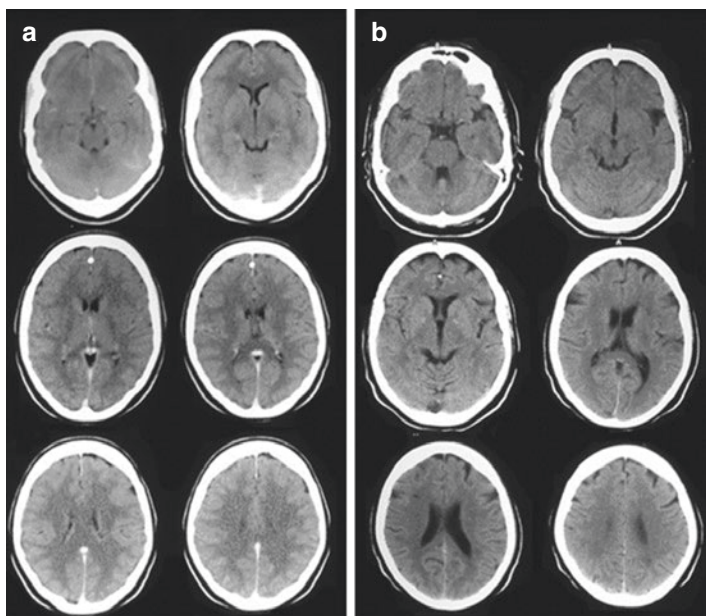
Non-contrast CT scan showing normal variations in the size of the lateral ventricles of two adults (a) and (b). Similar to Fig. 4.9b, the adult CT with larger ventricles (b) also show narrow occipital and frontal horns along with readily visible sulci making this a normal variant. Compare with Fig. 4.8 in which the frontal horn and occipital horn are rounded in appearance and the sulci are effaced
